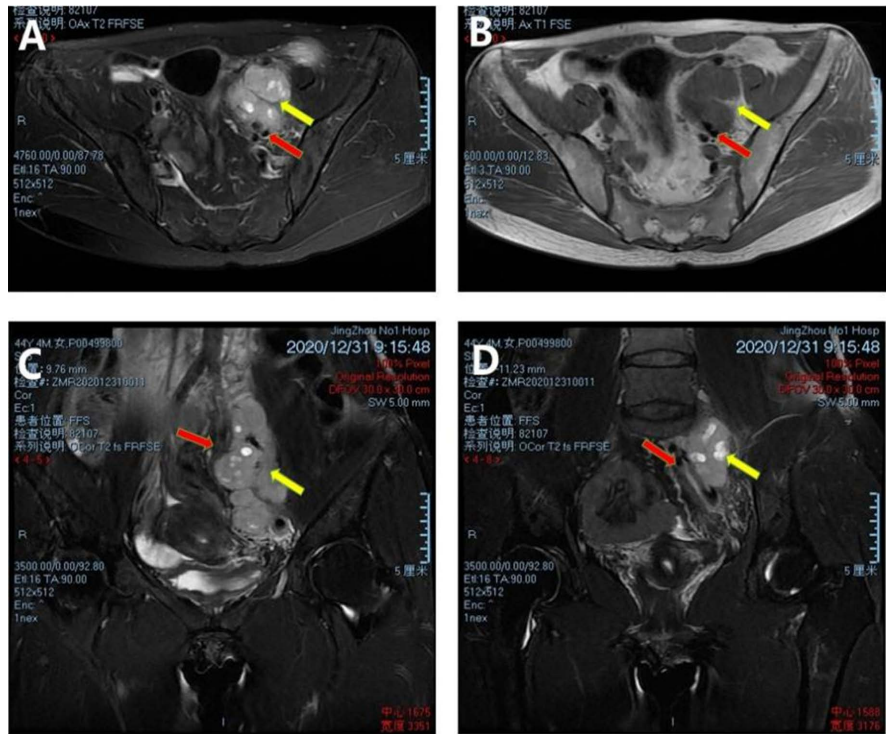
Pelvic MRI images are shown, (A)/(B) shows T1 and T2 images, and coronal images in (C)/(D). Red arrows mark the left internal iliac arteriovenous vein. Yellow arrows are the left retroperitoneal mass and visible calcifications. The left internal iliac AV was seen surrounded by a mass and pushed medially.
